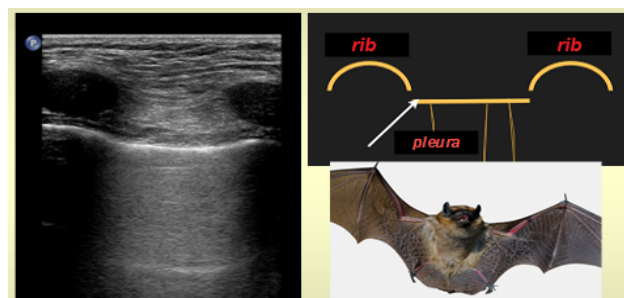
Two-dimensional ultrasound of healthy lungs. Ribs and the pleura outline the so-called "bat sign", where the pleura is the back of the bat and ribs are the wings of the bat.
